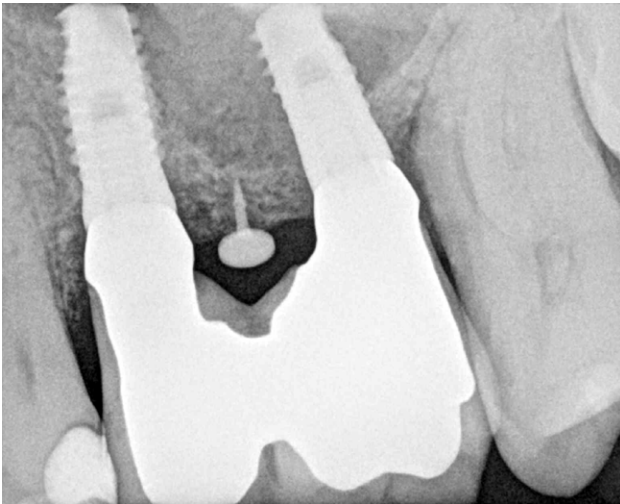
X-ray exam at 6 months of follow-up to case 1.
